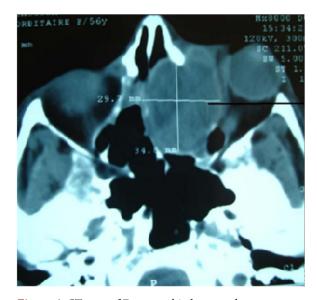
CT scan of Fronto-orbital mucocele.
